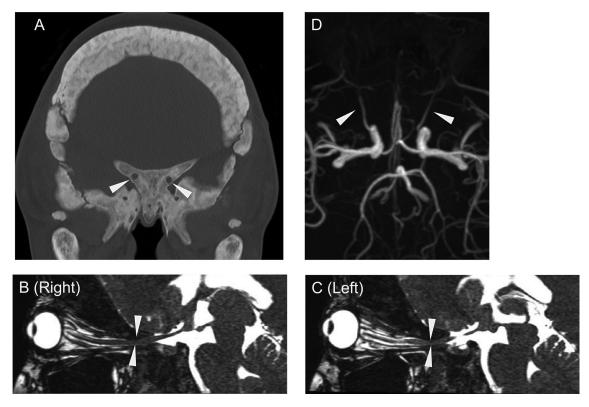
(A) Coronal CT image (bone window) showed markedly thickening of the whole skull, including around the optic canal (arrowheads). (B, C) There is bony thickening and narrowing of the bilateral optic canals. The degree of narrowing was not different on the right and left (arrowheads). (D) Bilateral ophthalmic arteries were well visualized by MRA (arrowheads).
